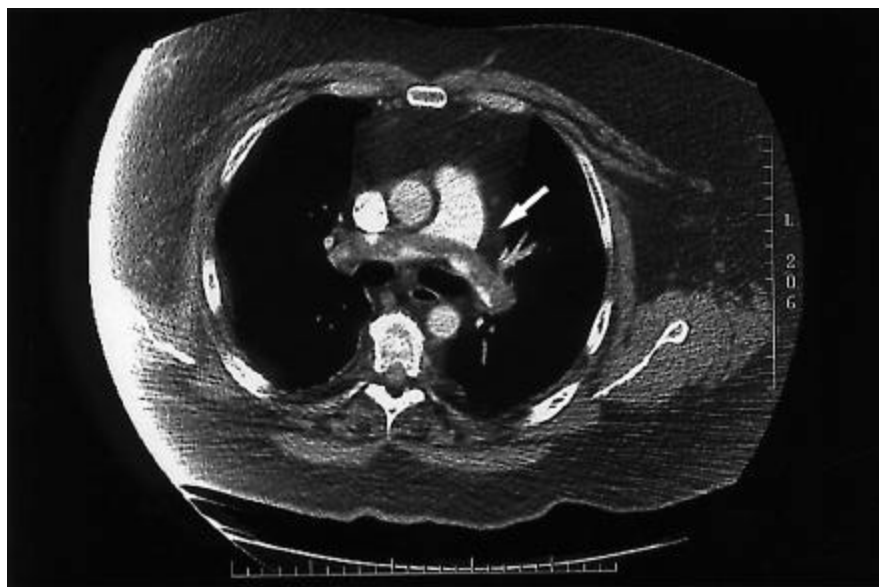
Spiral computed tomographic chest imaging with intravenous contrast material shows a massive filling defect that involves the right, left, and main pulmonary arteries.
